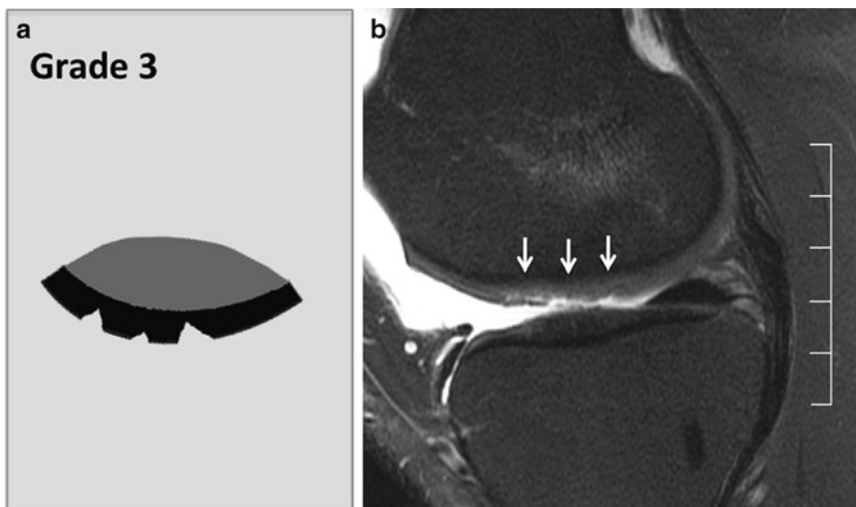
Whole-Organ-MRI-Score (WORMS) grade 3 lesion.* Graph of grade 3 knee cartilage lesion (a) and sagittal fat saturated intermediate weighted fast spin echo sequence of the knee (b) showing a cartilage WORMS grade 3 lesion at the central weight-bearing portion of the medial femoral condyle. The focal lesion measures more than
